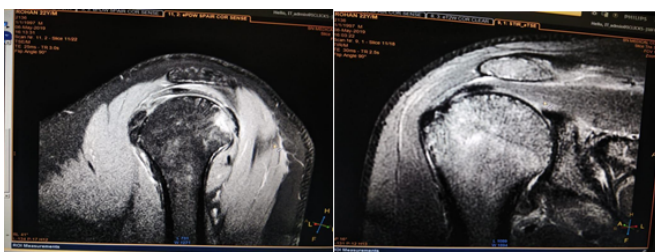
MRI coronal (A) PDW and (B) STIR images showing Hill Sach's lesion.
